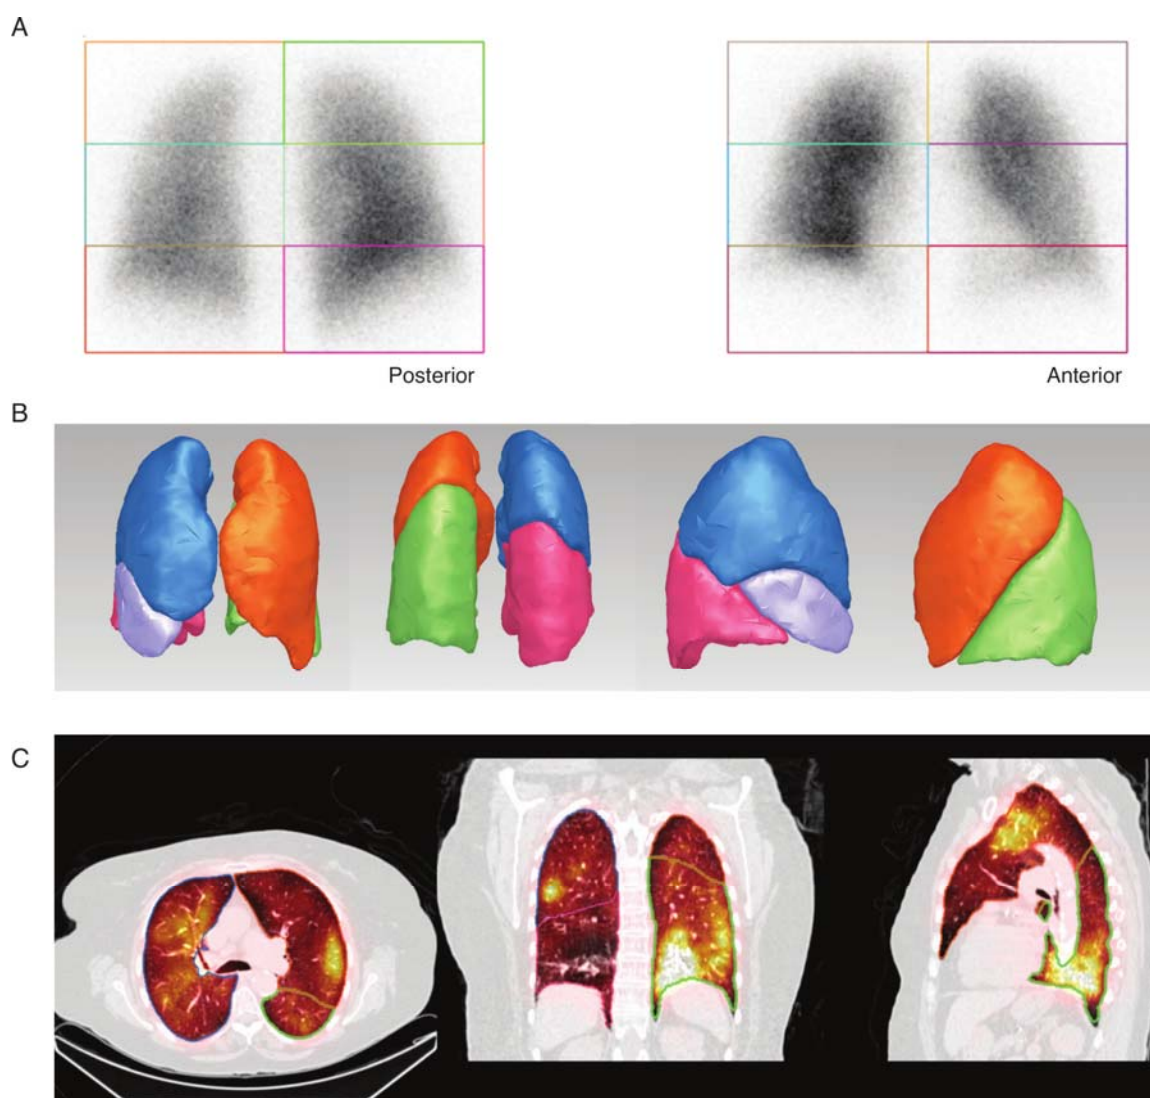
Quantification of perfusion using the planar method (A) and the semi-automatic SPECT/CT-based lung segmentation software (B-C).
